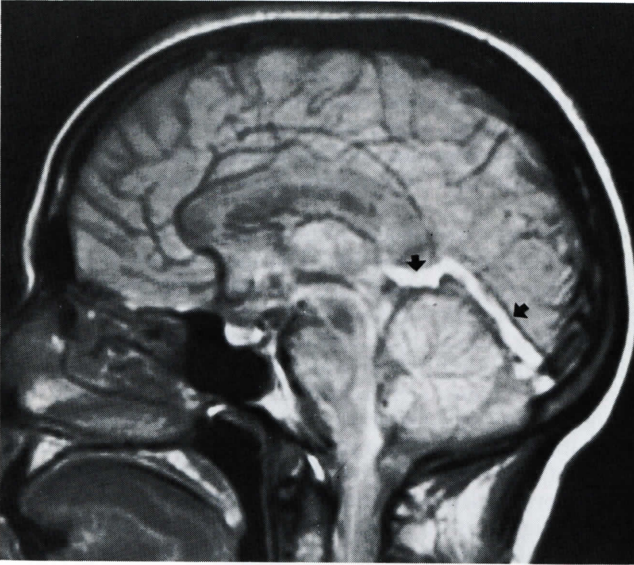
MRI scan of T2-weighted (first echo) hypersignal indicating vein of Galen and straight sinus thrombosis (arrows).
